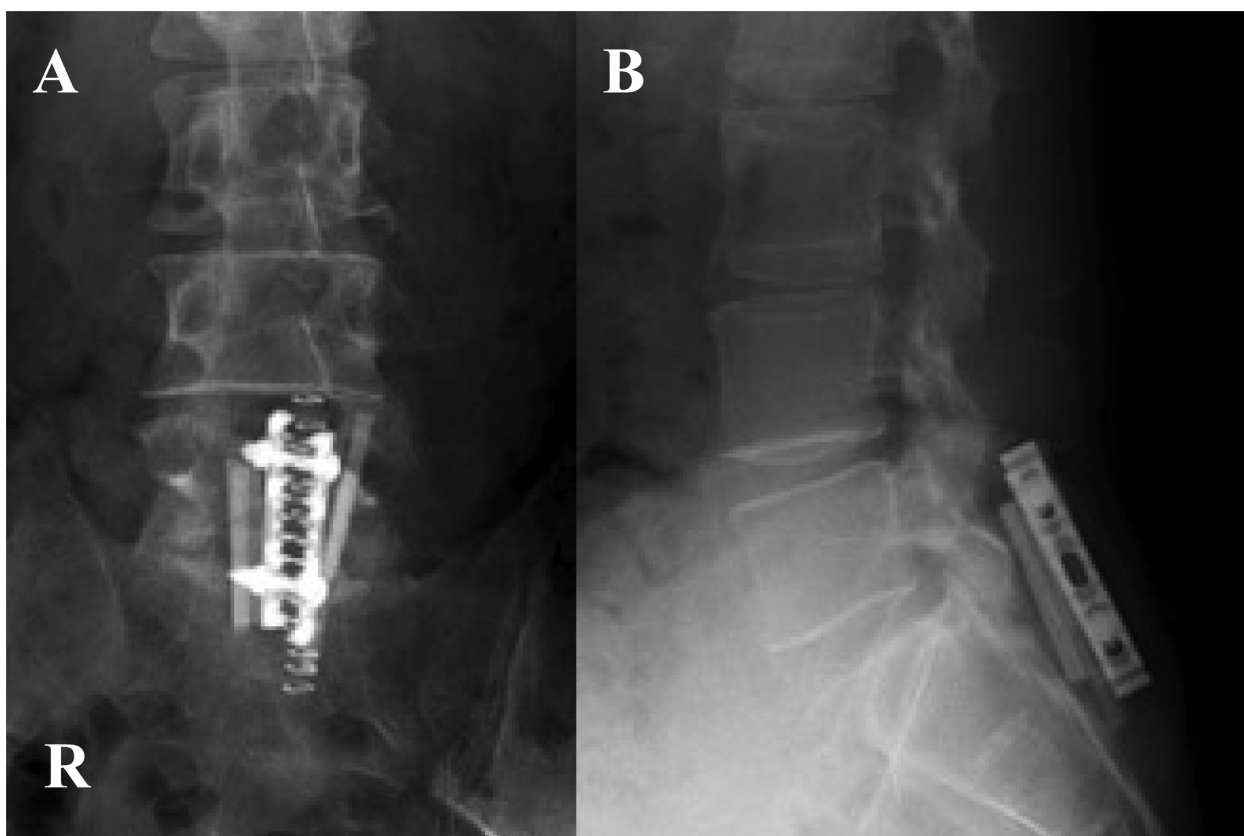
Post operative X-ray films. A) Anteroposterior (A-P) view. B) Lateral view. The S-plate was fixed between the L5 and sacrum and ceratite sticks were placed in the interlaminar space.
